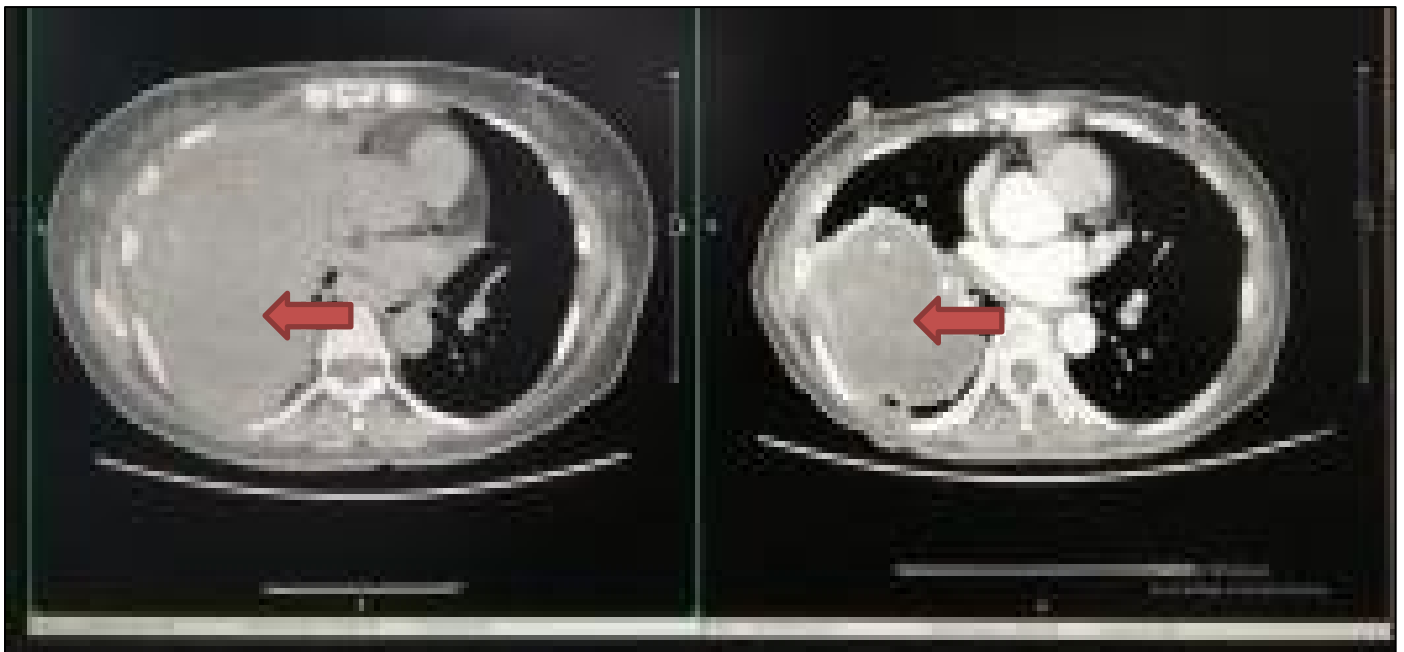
Comparison of chest CT scan of lung masses before (left) and 3 months after (right) consumption of Afatinib.
